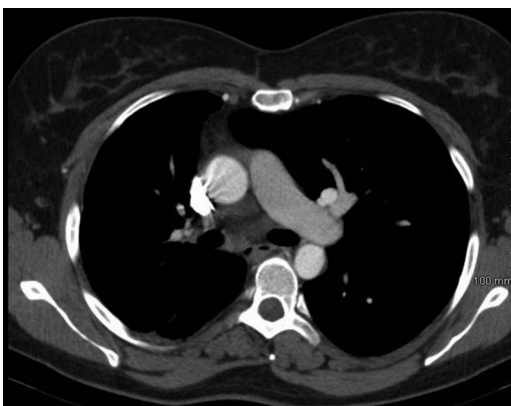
CT thorax showing the absence of the right pulmonary artery.
